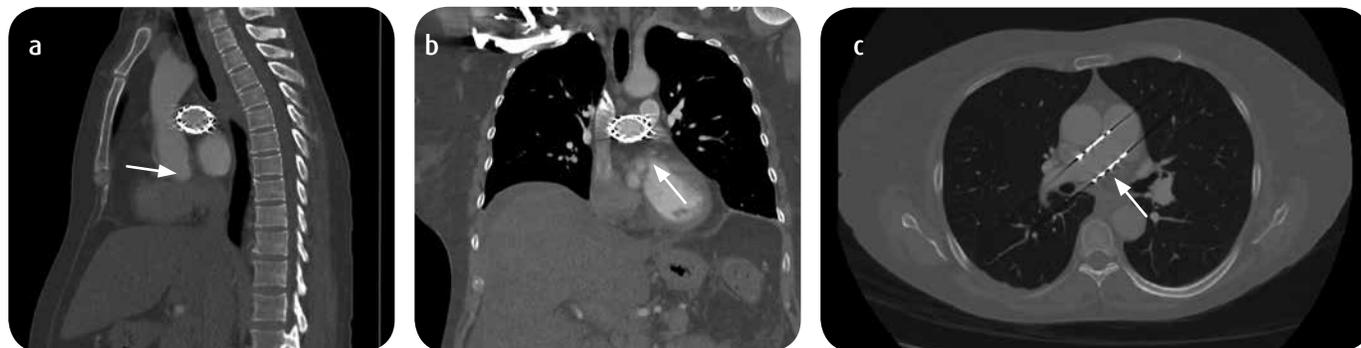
Chest CT angiography. Indicated initially due to suspicion of TEP. a-c) The embolized endoprosthesis is evidenced in the pulmonary trunk with projection towards the right AP (arrow). Proper alignment and apposition of the stent with respect to the pulmonary vessels.
